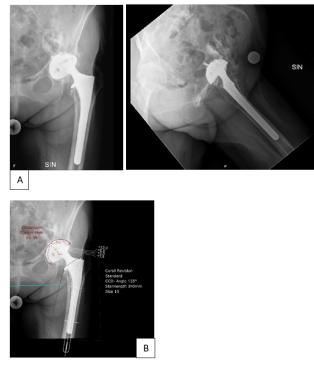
(A) Pre-operative x-ray of the left hip joint; (B): X-ray of the preoperative planning of THR
